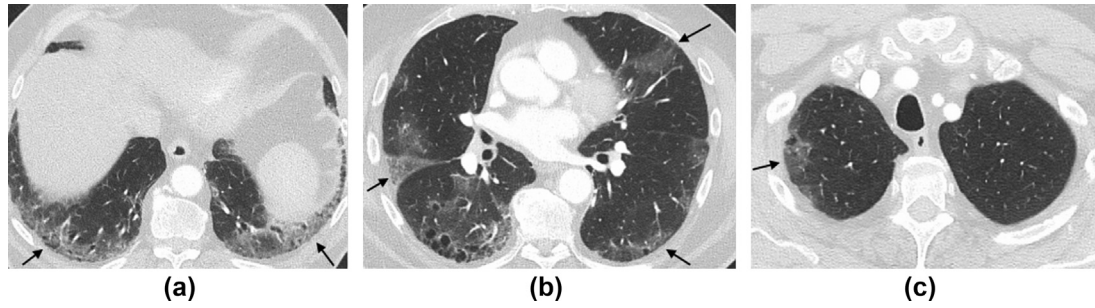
Patient with classic/probable COVID-19 CT features (black arrows) identified at (a) lung base, (b) limited chest (below carina), and (c) whole chest (above carina).
